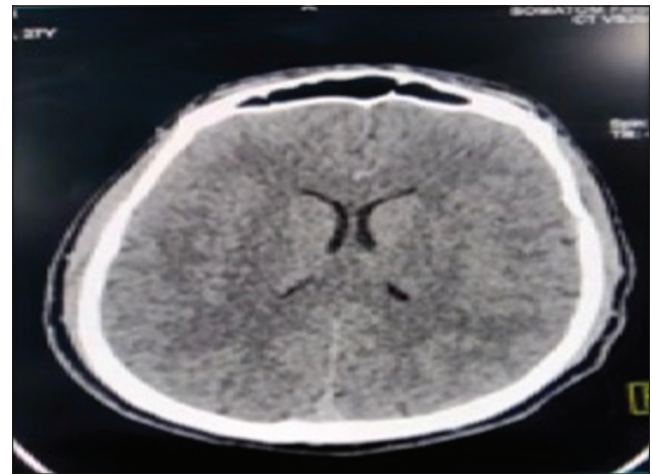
Non-contrast CT of the brain showing cerebral edema
